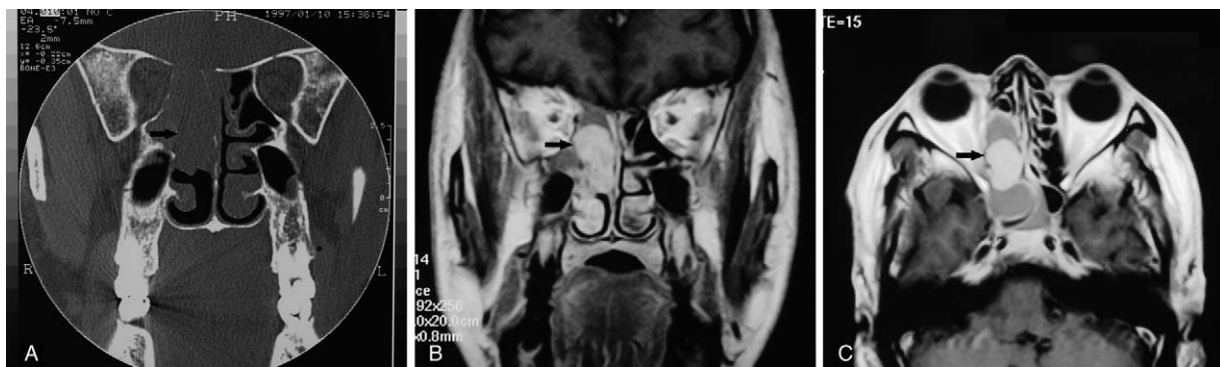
(A–C) ccRCC metastasizes to the right ethmoid sinus. (A) Coronal computed tomography (CT) of nose and paranasal sinuses reveals a mass in the right ethmoid and sphenoid sinus, with bone resorption of the superior wall of the sphenoid sinus. (B) Coronal magnetic resonance imaging (MRI) of the nose and paranasal sinuses shows a strong, enhanced lesion with a clear boundary. (C) Axial MRI demonstrates a hypervascular sinonasal tumor at the right ethmoid sinus. ccRCC = clear-cell renal cell carcinoma, CT = computed tomography, MRI = magnetic resonance imaging.
